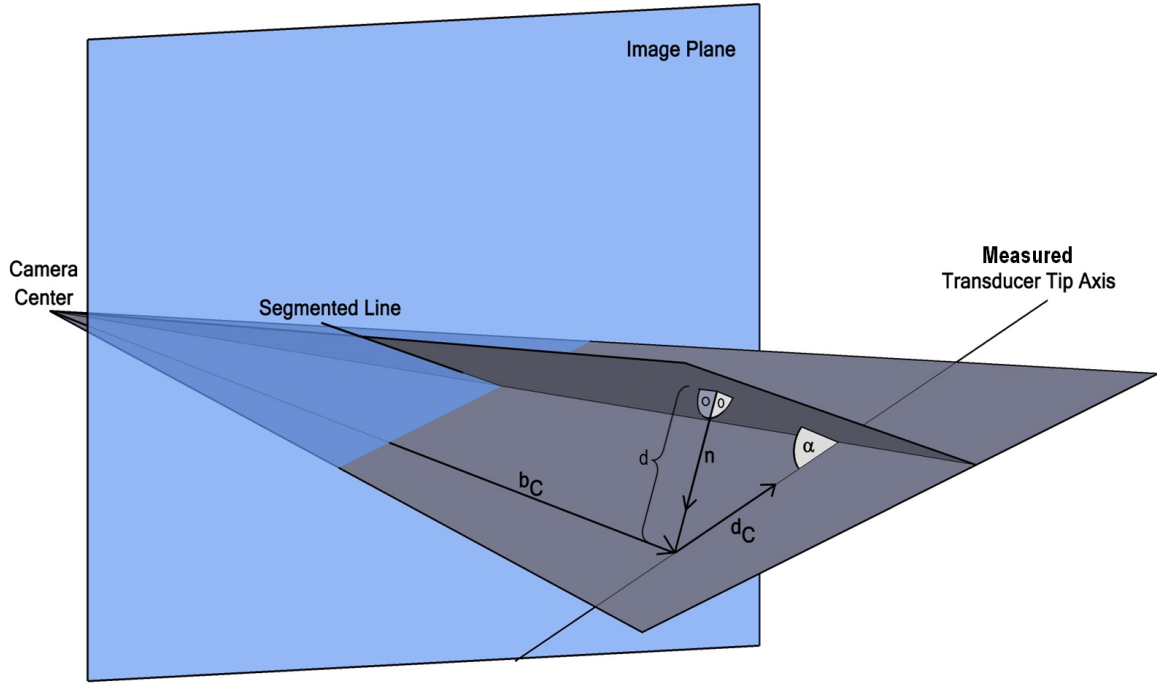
Back-projection of a segmented ultrasound transducer edge and its comparison to the transducer tip axis measured by electromagnetic tracking.
